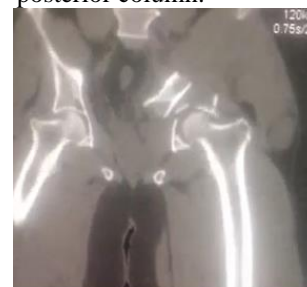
Preoperative computed tomography scan showing the avulsed posterior column displaced medially and anteriorly.
